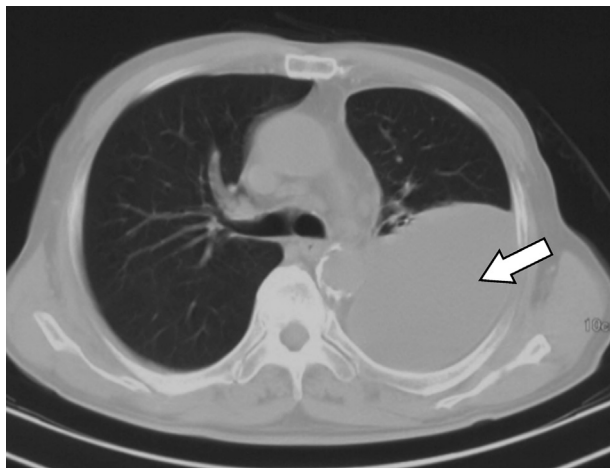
Computed tomography of the chest taken on the day before hospitalization at the referring facility. An open arrow indicates pleural effusion in the left thoracic cavity.
